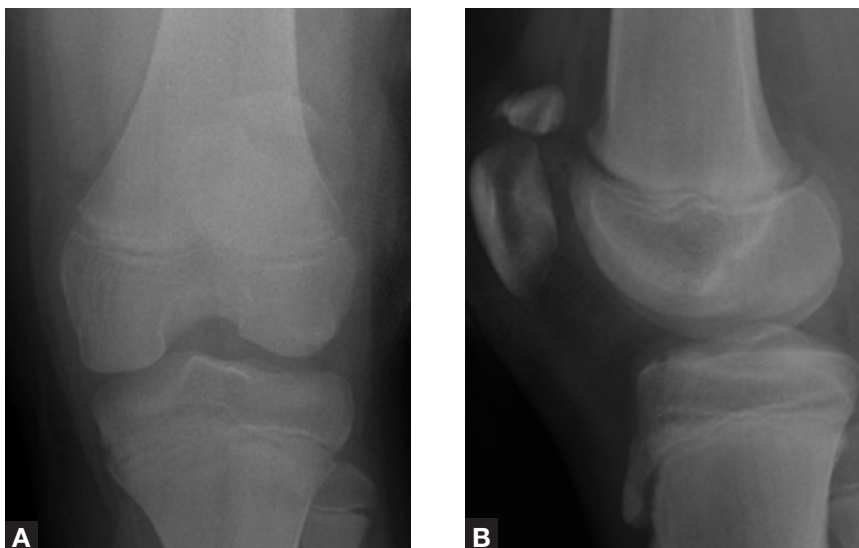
Case 1—Initial anteroposterior (A) and lateral (B) x-rays of open left patella fracture in a boy 10 years 8 months old.
